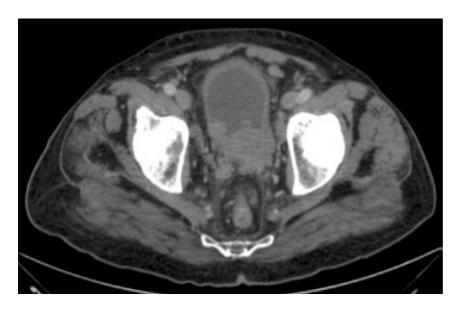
CT of pelvis showing prostatic tumour which has extended into the (thick-walled) bladder and spread to involve pelvic lymph nodes: the patient had multiple lower urinary tract symptoms
